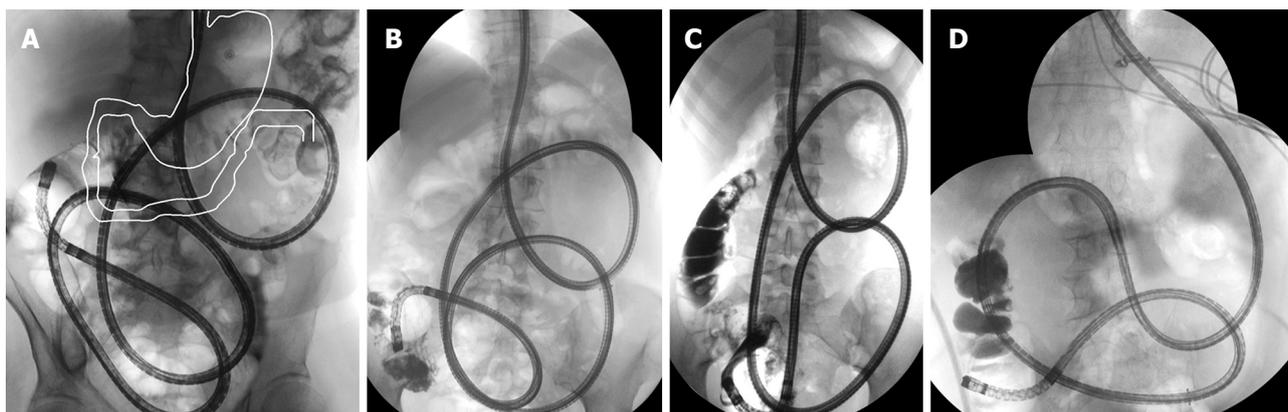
DBE, panenteroscopy *via* oral approach (plain radiograph) in supine position. In comparison with the normal situation (A, white outline), the duodenum is shifted markedly to the left, straightened and shortened. A-C: Normal anatomy; D: After B II resection.
